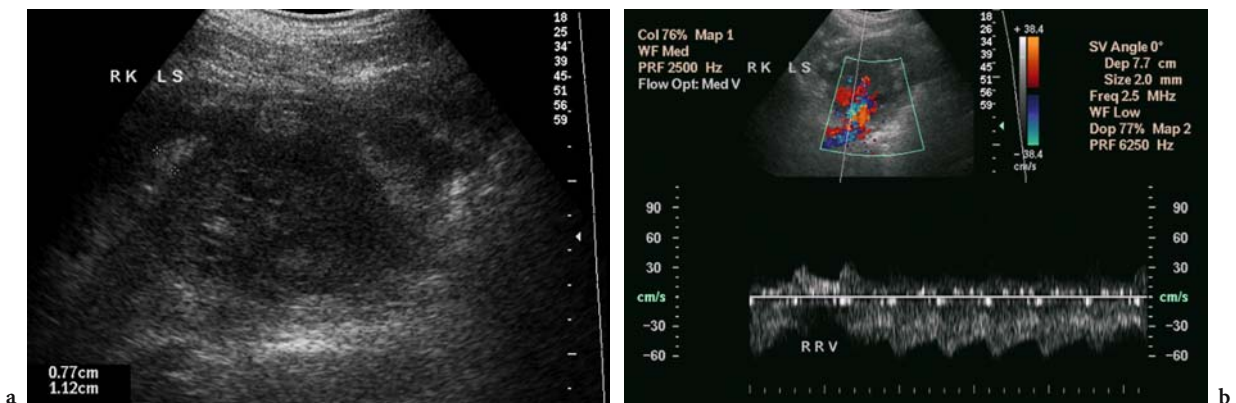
Acute myeloblastic leukemia in a 59-year-old man. a Longitudinal ultrasound image of the right kidney shows echogenic tissue (calipers) surrounding the kidney in the perinephric space. b On Doppler ultrasound image, the renal hilar vessels are noted to be patent.
